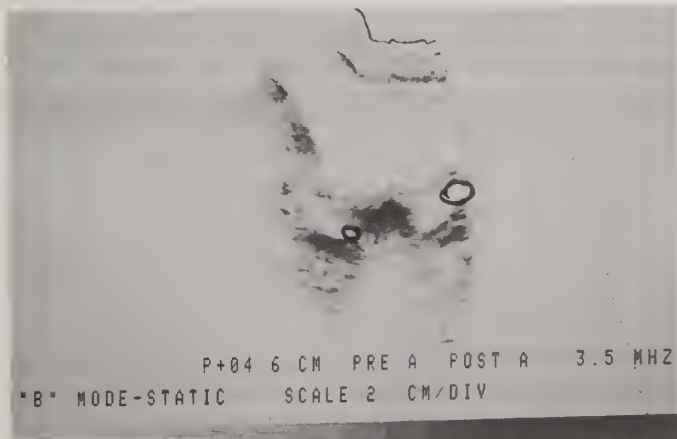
Pelvic Sonogram. A transverse view 4.6 cms. above xymphisis reveals enlarged left ovary measuring 4 x 2.5 cms. with a 1.5 cm. cyst. Right ovary measures 2 x 2 cms. with a 0.5 cms. cyst.
